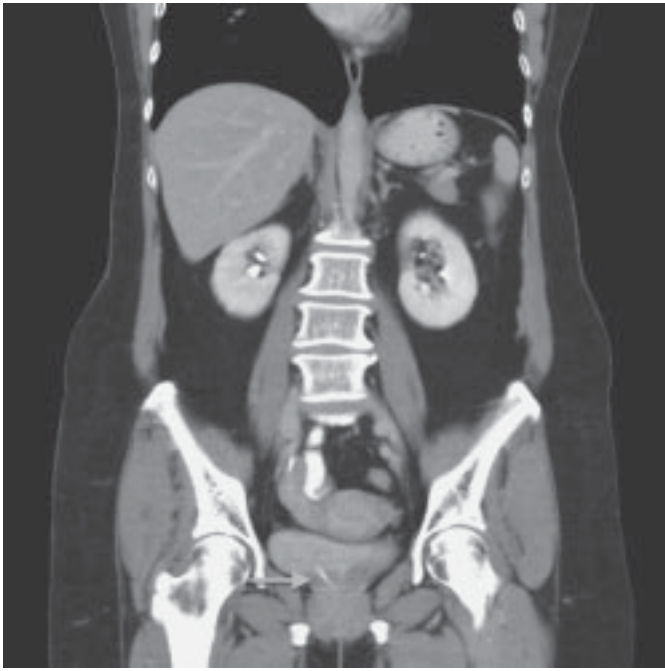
Reconstructed contrast-enhancing computed tomography in the excretory phase shows contrast through the right ureter directly passing to the bladder neck.
